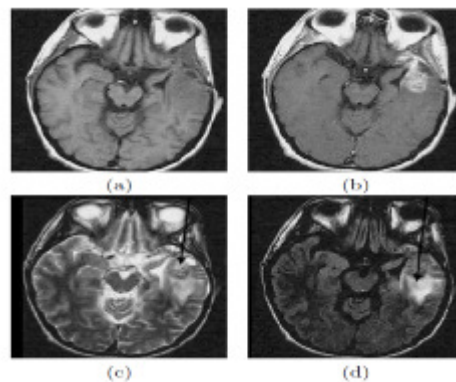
MRI of brain. (a) T1-weighted image without contrast enhancement. (b) T1-weighted image with contrast enhancement. (c) T2-weighted image. (d) FLAIR Image
